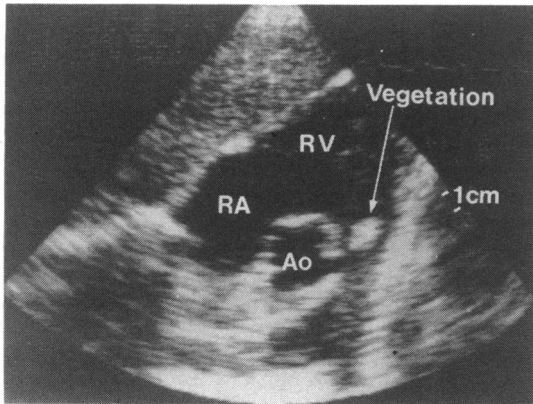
Cross-sectional echocardiogram of the right side of the heart from the subxyphoid region. A 2 cm mass attached to the pulmonary valve is clearly evident. RA, right atrium; RV, right ventricle; Ao, aortic root.
